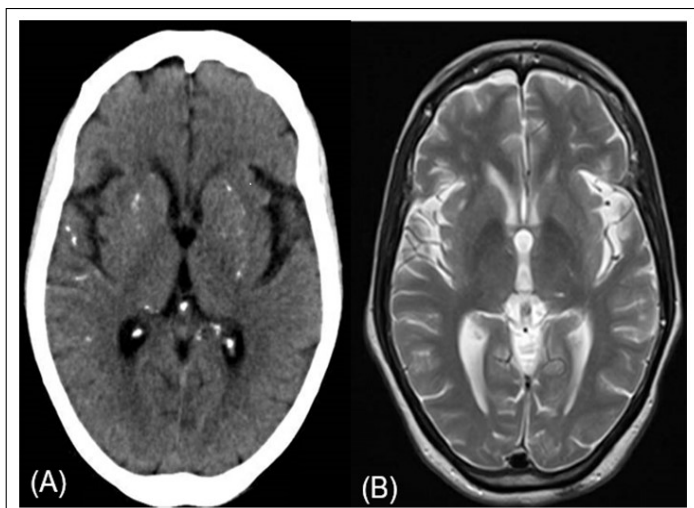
Calcifications in basal ganglia and right temporal lobe. (A) Axial Brain CT, (B) Axial MRI T2 sequence. CT visualization superior to MRI
